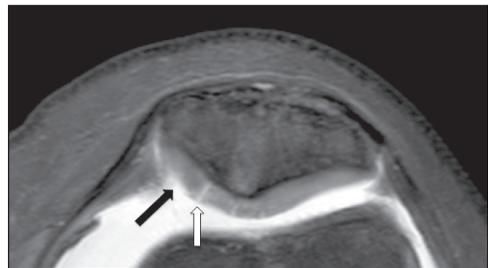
44-year-old, male. T1-weighted MR image shows focal breakage in cartilage surface of medial facet (white arrow), marked cartilage loss in medial facet (black arrow) consistent with grade 2-3.
